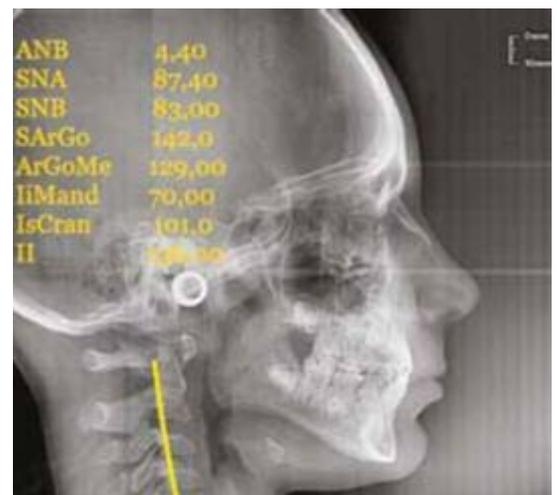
radiography at 1 year of elastodontics therapy: clear improvement
